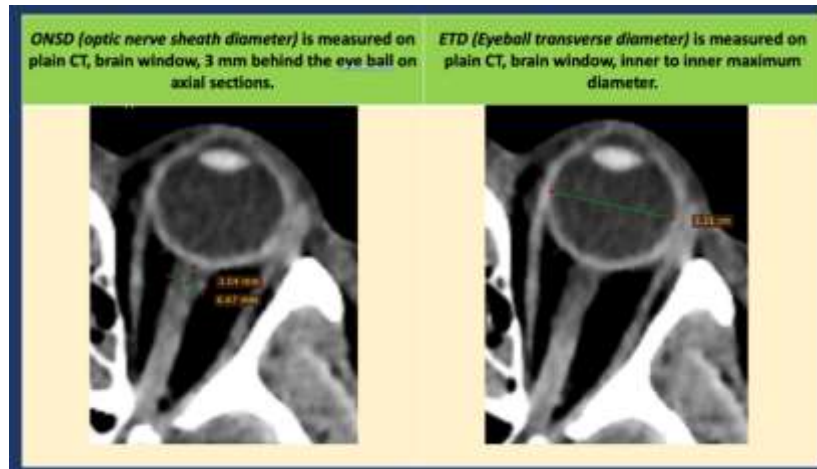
CT scan of ONSD and ETD.
